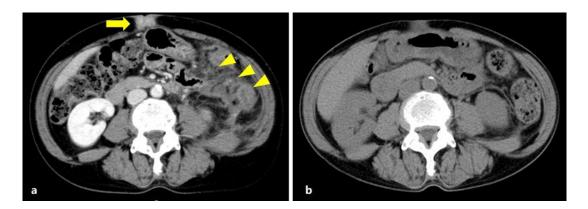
a Contrast-enhanced computed tomography (CT) image of the abdomen. A high-density node in the umbilical area (arrow) and elevated peritoneal concentration reflecting peritoneal dissemination (arrowheads) were observed. b Plain CT image of the abdomen. After the start of chemotherapy, the umbilical node was reduced and peritoneal dissemination was improved.
